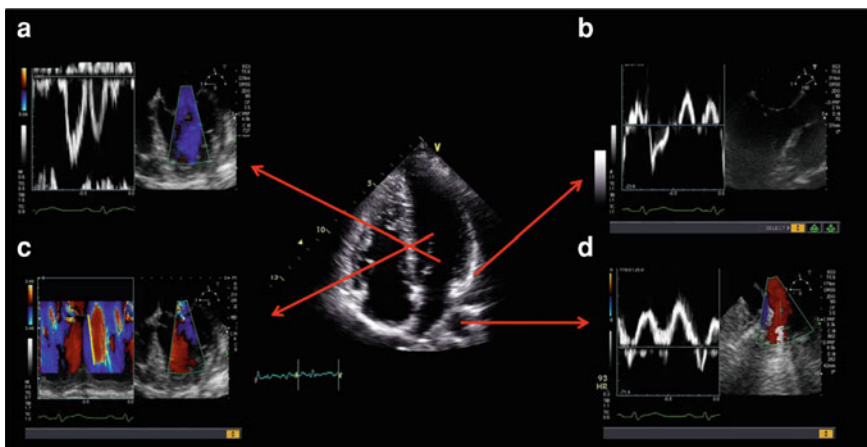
Some parameters routinely used to estimate left atrial pressure. a Transmittal PW Doppler. b LV tissue Doppler imaging. c Colour M-mode velocity propagation. d Pulmonary vein PW Doppler. Of these, the best correlate with left atrial pressure is the deceleration time of the pulmonary vein D wave (white arrow), however, none are well-validated in the ICU and should generally be used in combination, and in the context of the comprehensive echocardiographic study. PW; pulse wave, LV; left ventricle, D wave; diastolic wave, ICU; intensive care unit
